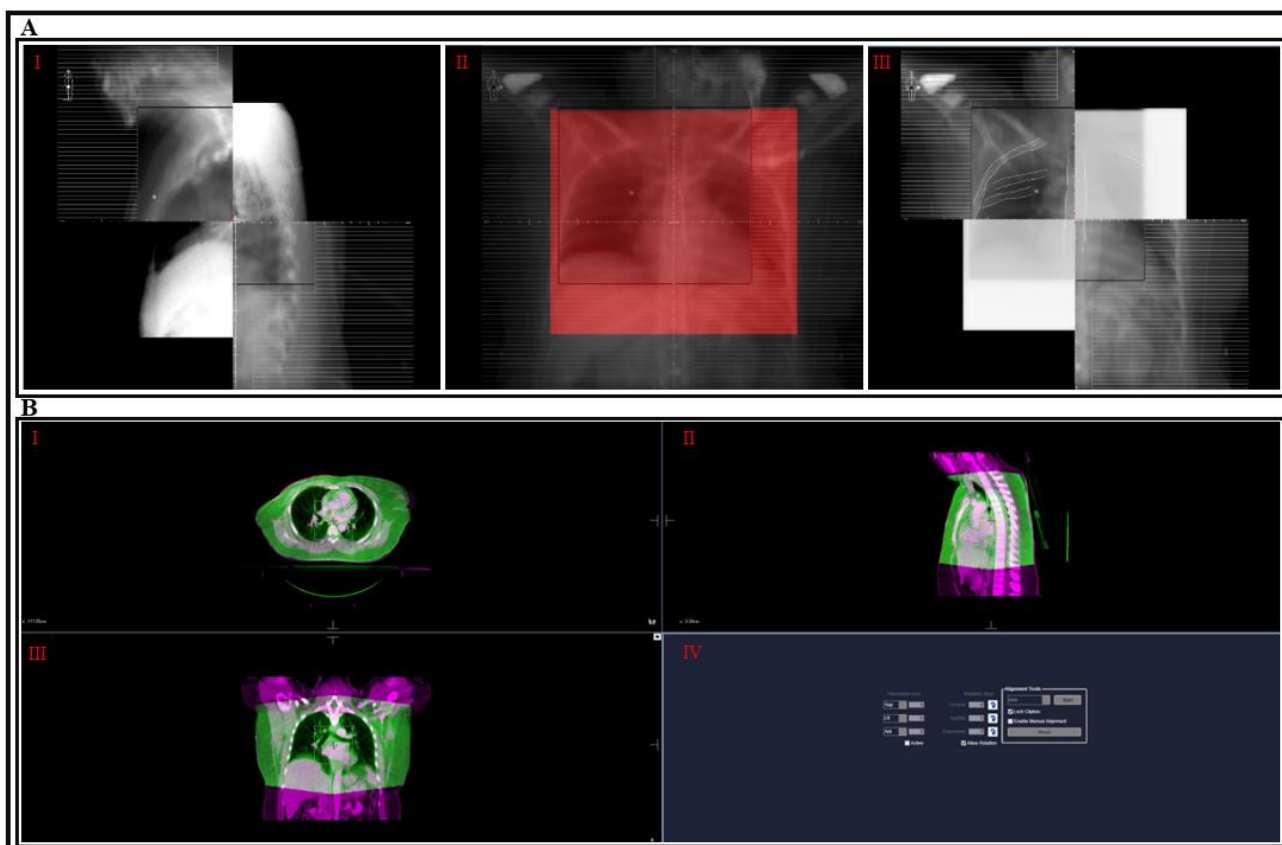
A showcase of (A) electronic portal images (EPID) taken daily from days 1 to 3, and (B) cone-beam computed tomography (CBCT) performed on a weekly basis.
